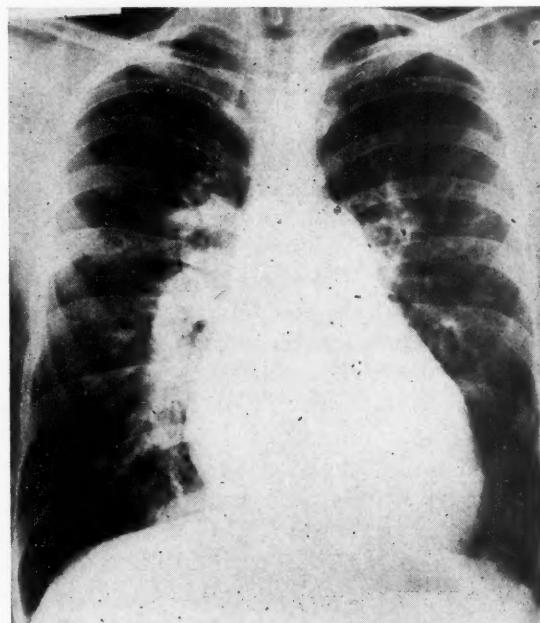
Posteroanterior roentgenogram of thorax.
